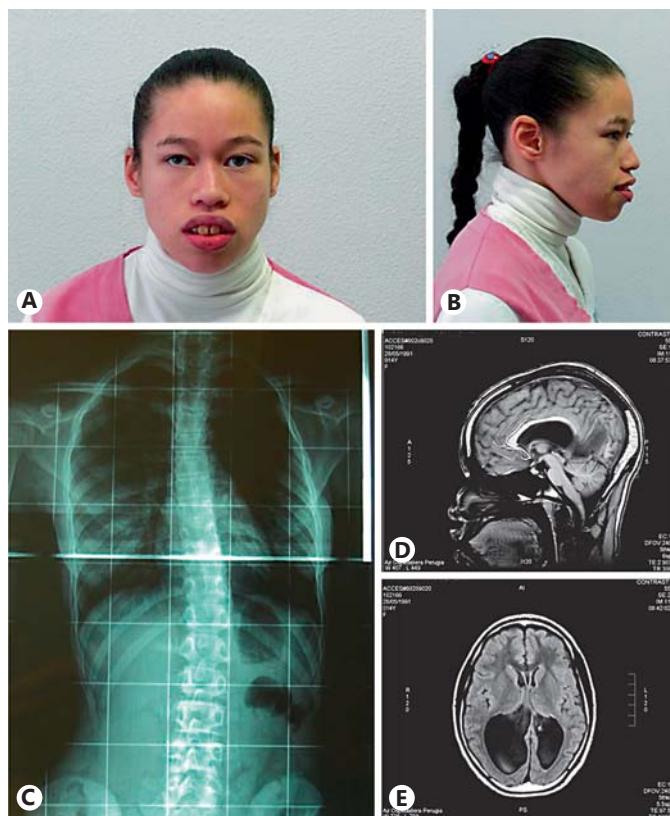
A, B Note the facial dysmorphisms of the patient, in particular the strabismus, high forehead, fullness of periorbital region, prominent premaxilla, prognathism, short philtrum, open-mouth appearance, long mandible, thick lips. C Anterior-posterior X-ray projection of the vertebral column showing the moderate scoliosis. The MRIs show the partial agenesis of corpus callosum (D) and ventriculomegaly with gross cerebral asymmetry (E).
